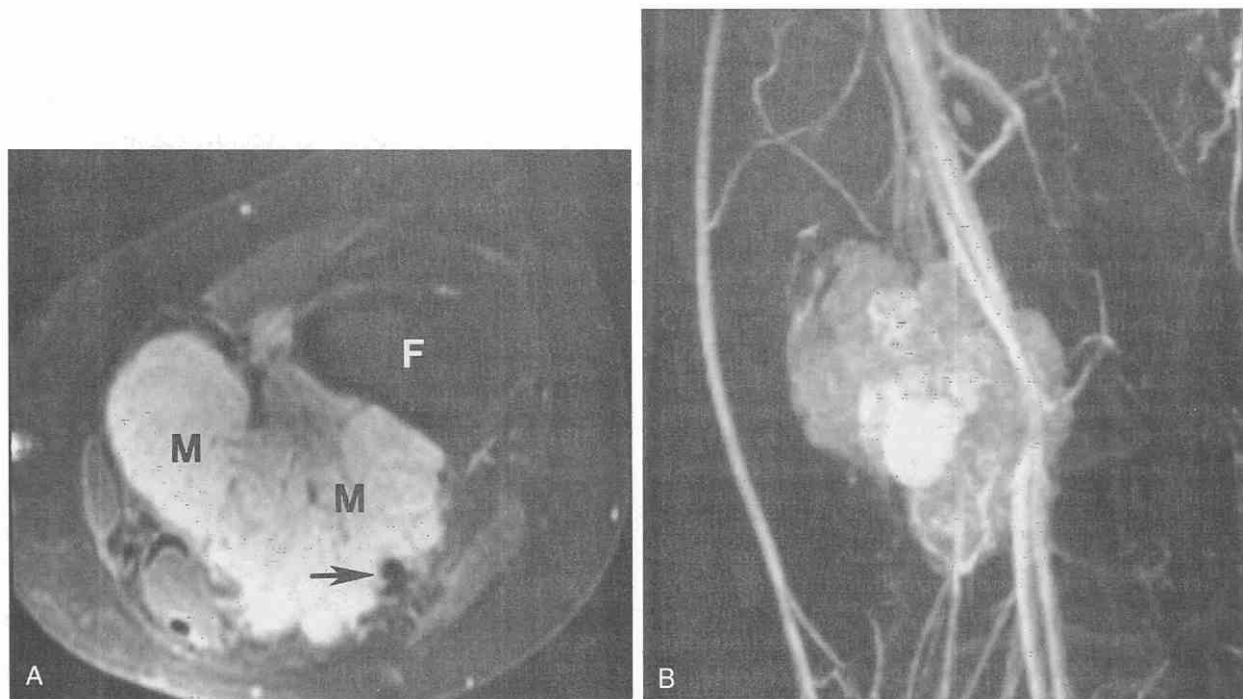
Synovial sarcoma of the popliteal fossa in a 7-year-old girl. *A*, Postgadolinium axial T1-weighted image (TR = 500 msec, TE = 8 msec) with fat saturation shows a multilobular mass (M) abutting the posterior margin of the femur and partially encasing the neurovascular bundle (arrow). *B*, Coronal maximum intensity projection time-of-flight image (TR = 7.8 msec, TE = 2.4 msec, flip angle = 45 degrees) showing the three-dimensional relationship of the mass to the vasculature. Imaging was performed after gadolinium enhancement, which accounts for the increased signal intensity of the mass.
